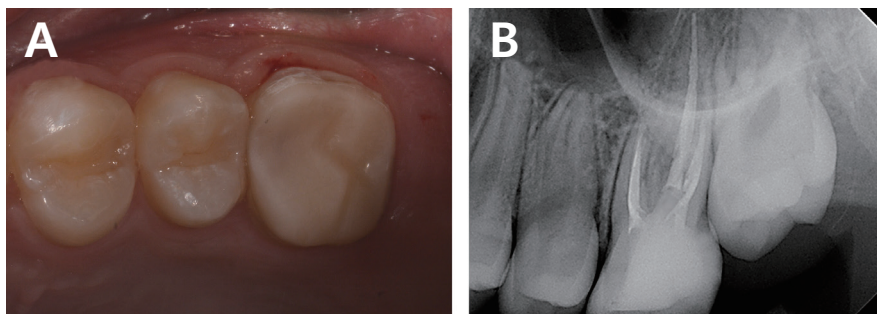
(A) Occlusal view, (B) Radiographic aspect after cementation of endocrown.
